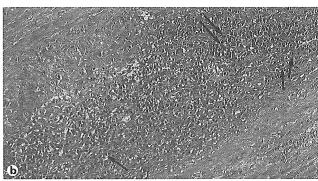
a Axial FDG PET showing diffuse FDG uptake in the thoracic aortic wall (arrowheads). b Arrows indicate representatives of macrophages englobing hemosiderin in the hematoma of the tunica media. HE. ×200.
